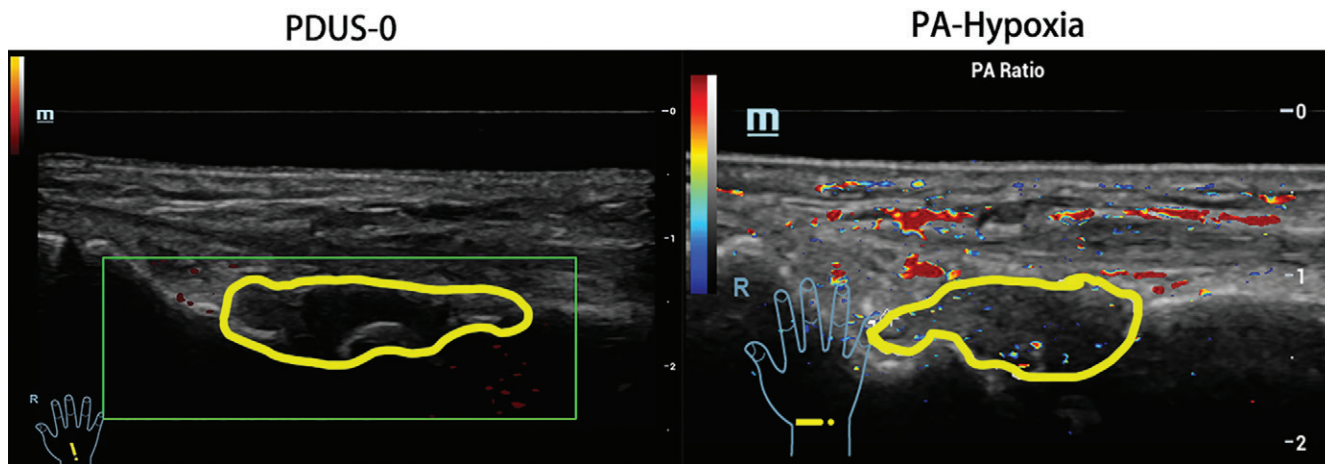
Example of power Doppler US (PDUS)–depicted hypovascularity and photoacoustic (PA) imaging–detected hypoxia. The longitudinal section of (left) PDUS and (right) PA oxygenation saturation (So₂) images in the right (R) wrist of a 65-year-old woman, who had lived with rheumatoid arthritis for 12 years and experienced recurrent wrist swelling and pain, show the wrist had a PDUS grade 0 (no signal; circled, left) and the wrist synovium was hypoxic based on the blue-dominant signals (circled, right) of PA-So₂ mapping. Imaging settings: luminous flux, less than 20 mJ/cm²; fluctuation, less than 5%; imaging gain value, 45–55 dB; color bar, 40%–100%. For image scoring methods, see Appendix E1 (online).
